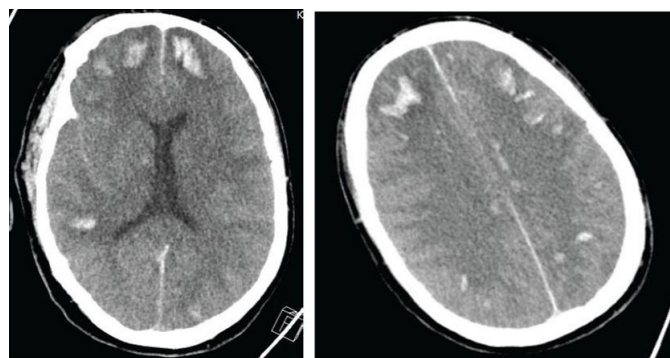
CT of head without contrast showing multiple small cerebral parenchymal hemorrhages bilaterally with diffuse brain swelling.
